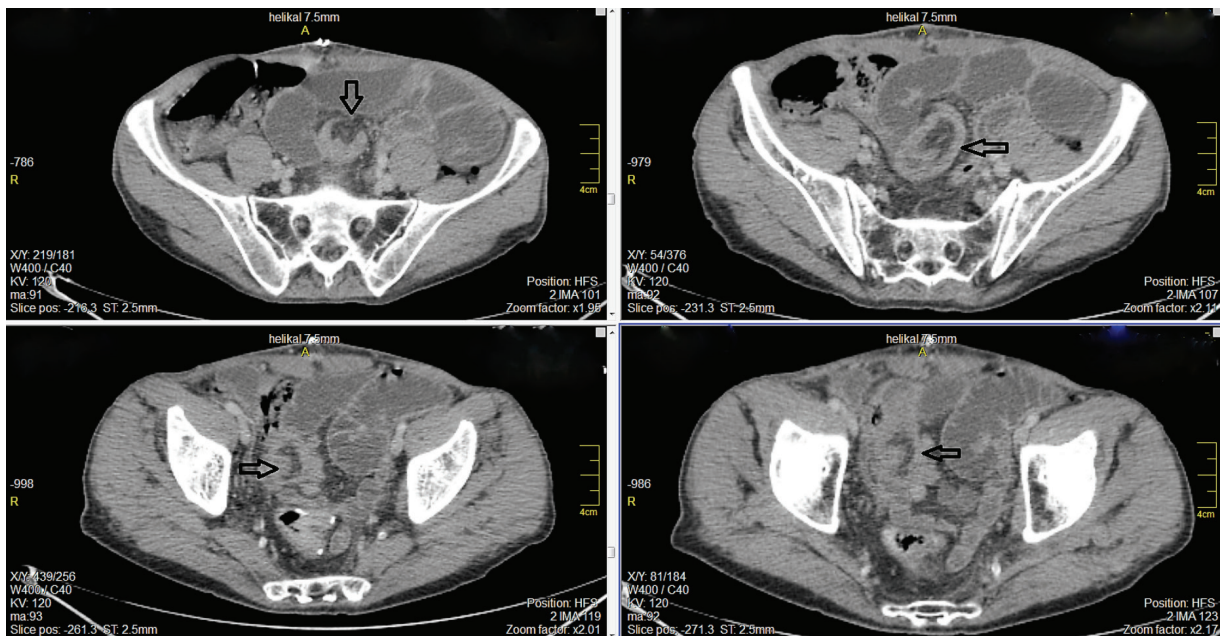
Computed tomography image showing small bowel intussusception
